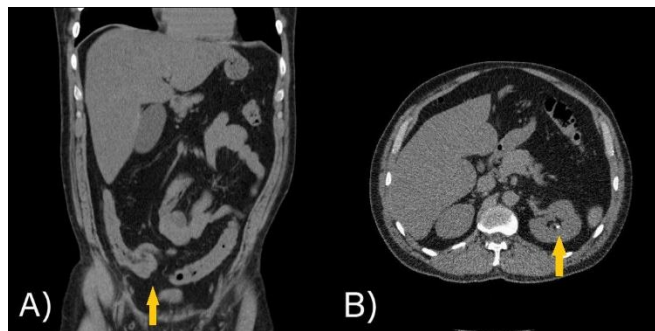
Abdominal CT scan. A) Coronal section, the yellow arrow shows absence of date of acute appendicitis. B) Axial section, the yellow arrow shows lithoid in left renal topography.
